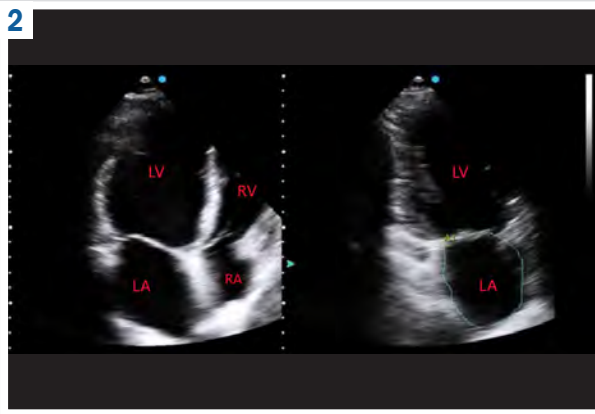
Transthoracic echocardiography: apical four- and two-chamber views. LA: left atrium; LV: left ventricle; RA: right atrium; RV: right ventricle.
